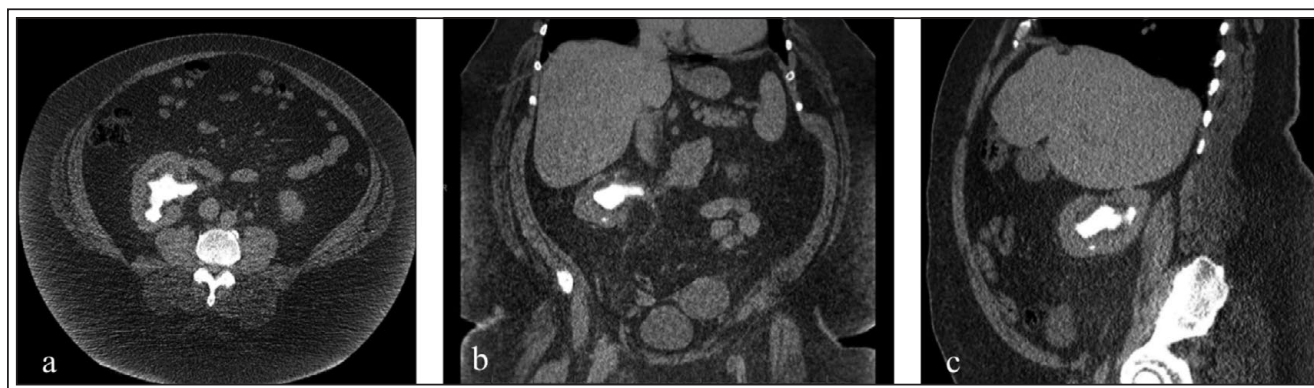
Super obese patient (BMI 85) with large volume right-sided stone a) axial b) coronal and c) sagittal images from CT abdomen and pelvis demonstrating right staghorn calculus.
